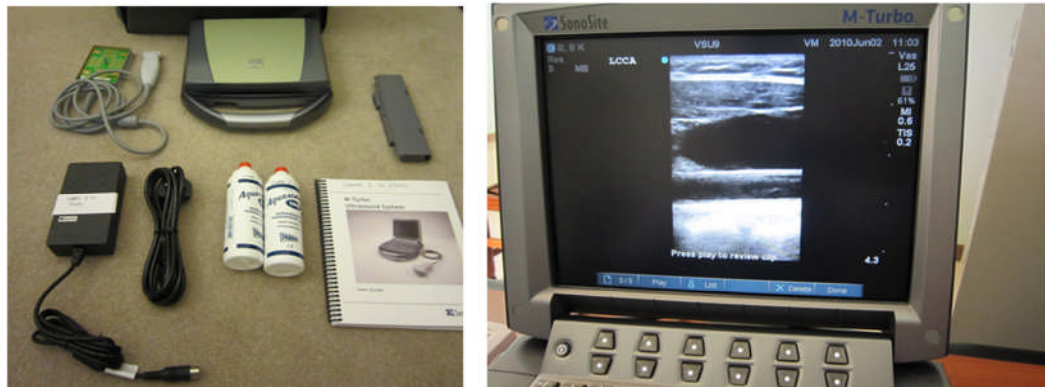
The Sonosite Micromaxx portable ultrasound machine.
